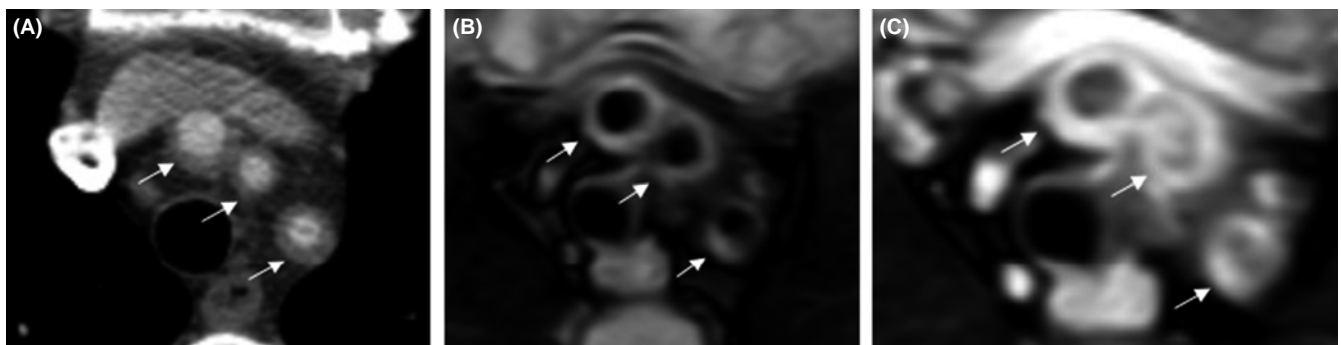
A, B, Computed tomography and magnetic resonance angiography, respectively, show increased wall thickness and luminal narrowing in the brachiocephalic, left common carotid, and subclavian arteries. C, Post-contrast series, all supra-aortic branches had circular enhancements
